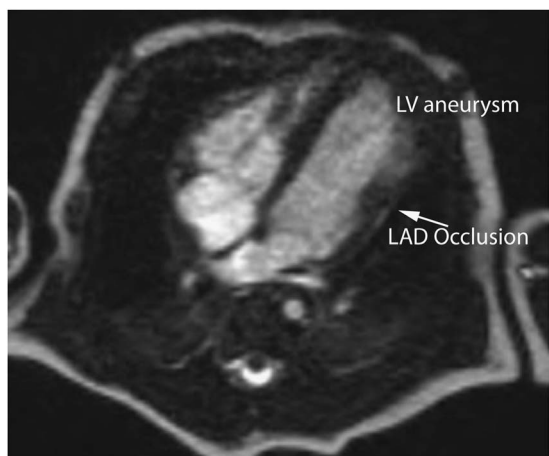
Cardiac MRI showing the left ventricular (LV) aneurysm and occlusion of the left anterior descending (LAD) coronary artery.
